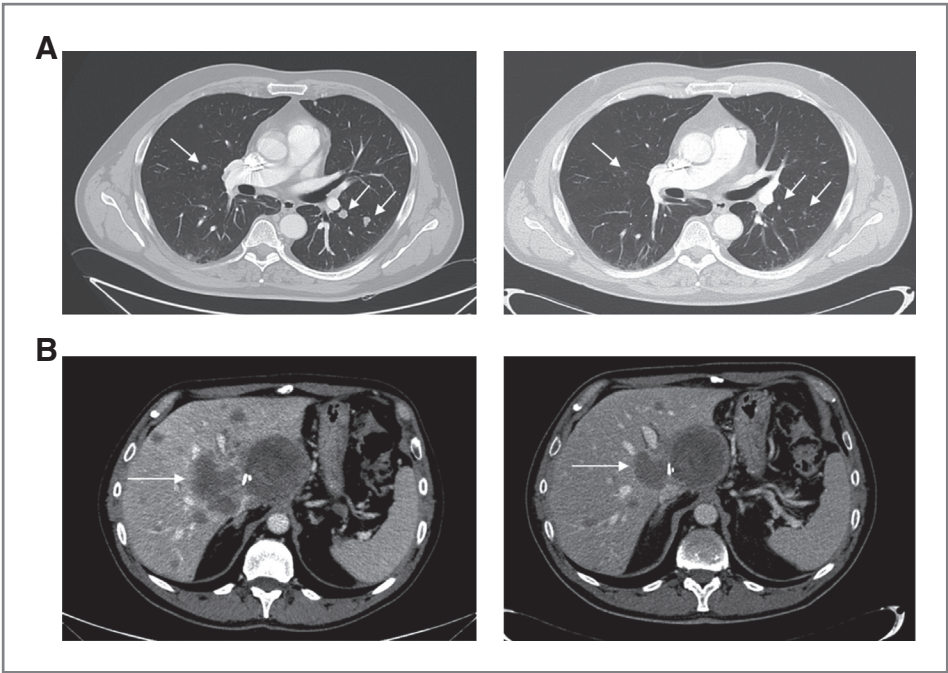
Computed tomography scan showing tumor shrinkage (white arrows) after treatment with dacarbazine in 2 patients, one with lung (A) and another with liver (B) metastases, both displaying *MGMT* promoter hypermethylation in primary tumor.
